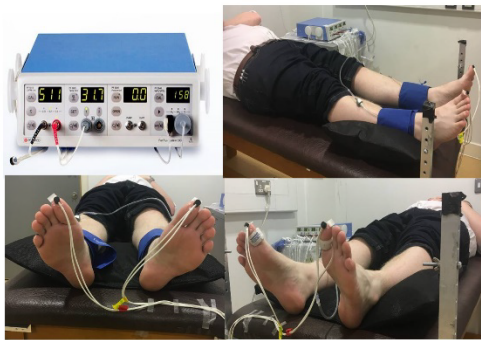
Laser Doppler Flowmetry system and lab setting
